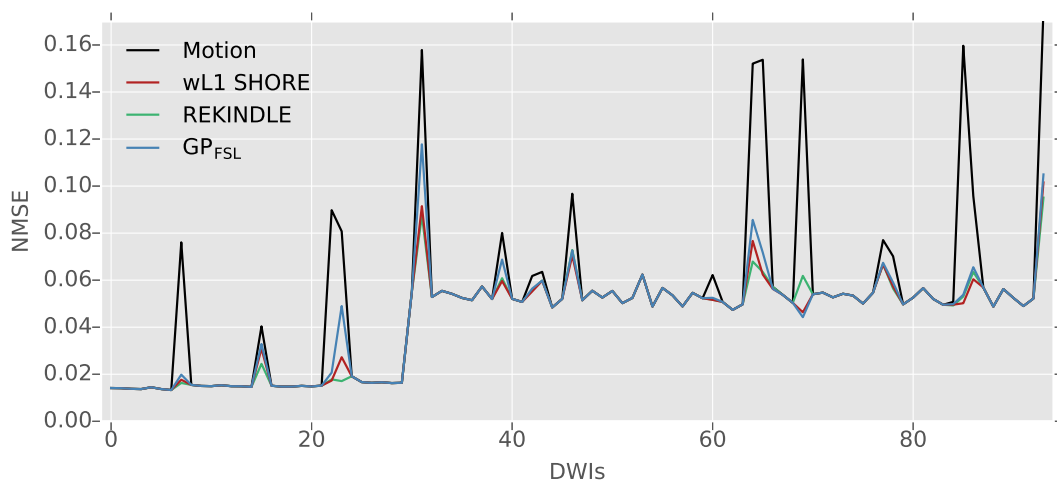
The NMSE computed per DWI between the reference and the motion corrupted *in vivo* research data is higher for DWIs with signal dropout due to deliberate fast head movements compared to DWIs not corrupted by this motion (Motion). Slice-based outlier detection and data correction is performed using wL1 SHORE, REKINDLE and GP FSL . All methods reduce the NMSE of motion corrupted DWIs, while non-corrupted DWIs are not modified. At low  $b$ -values, all methods perform comparable. At high  $b$ -values, lower NMSE values are obtained for wL1 SHORE compared to the other methods.
